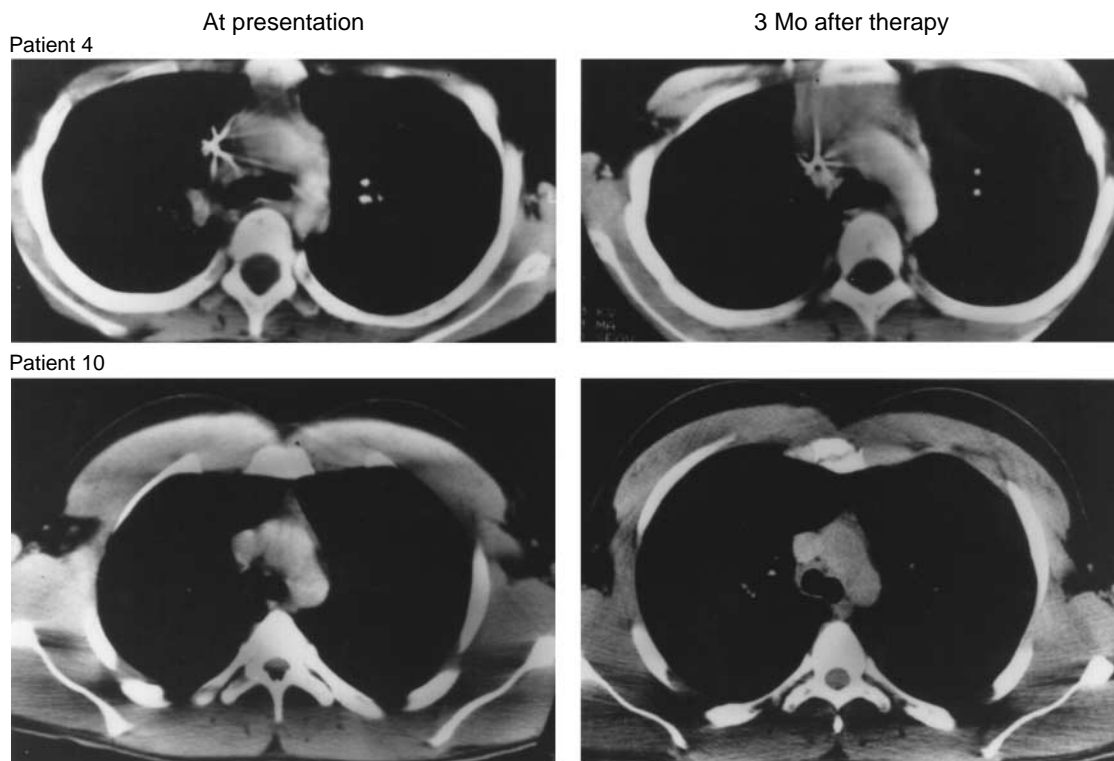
CT Scanning of the Thymus before and after Chemotherapy.
